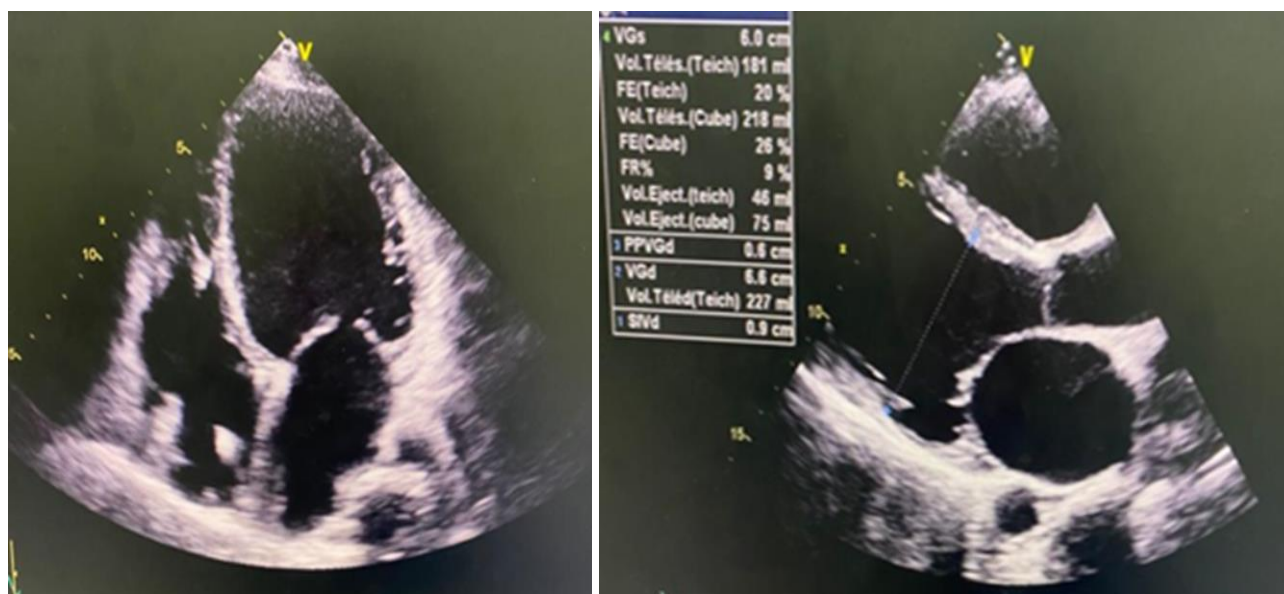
+3: Transthoracic echocardiography (apical four-chamber view) showing a markedly dilated left ventricle with global hypokinesis and spontaneous intracavitary contrast
